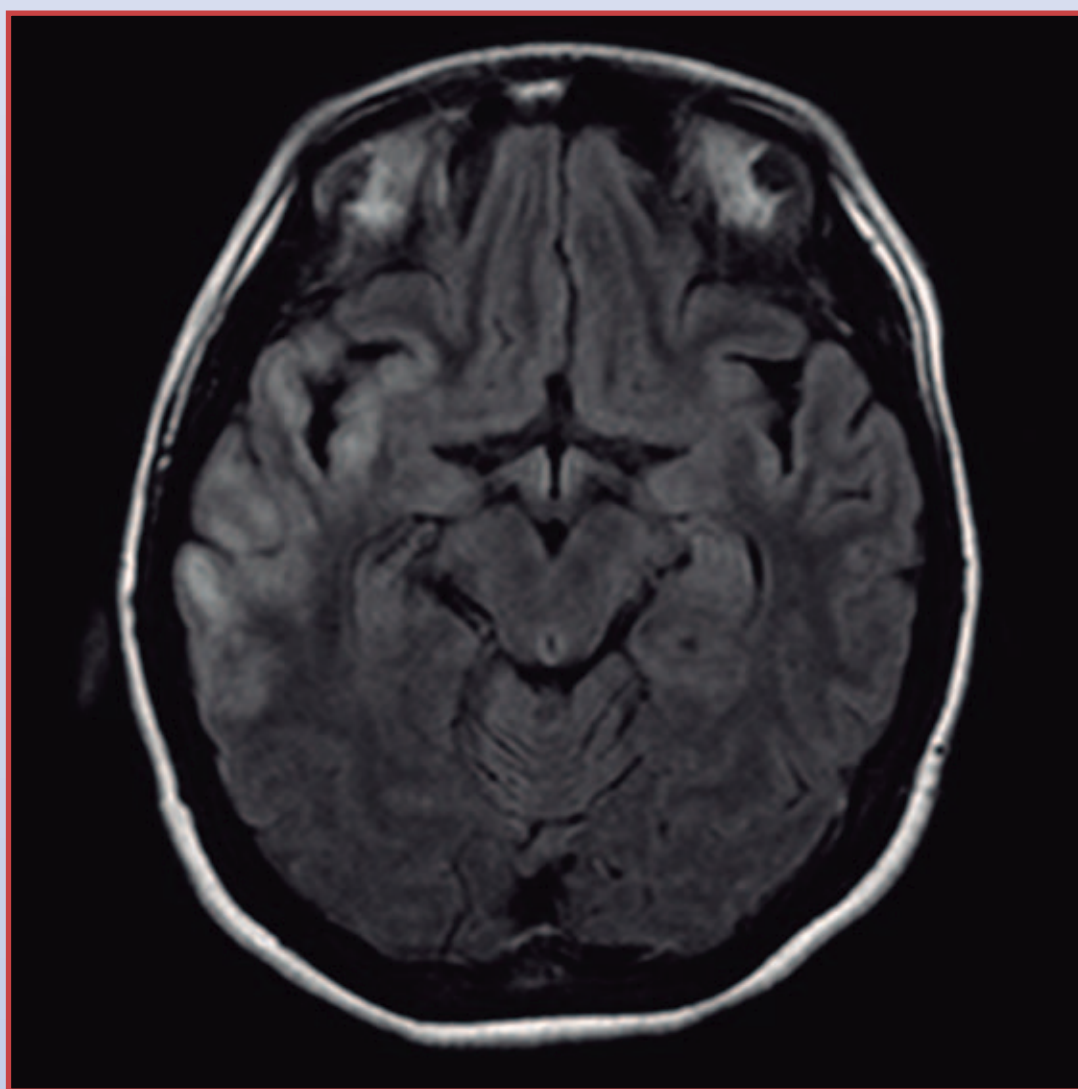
T2 weighted brain MRI (transversal) showing extensive area of increased signal in right temporal cortex and a hyperintense signal involving right occipito-temporal cortex.
